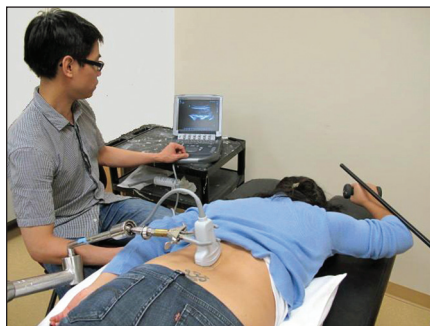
Experimental setup of ultrasound imaging.
